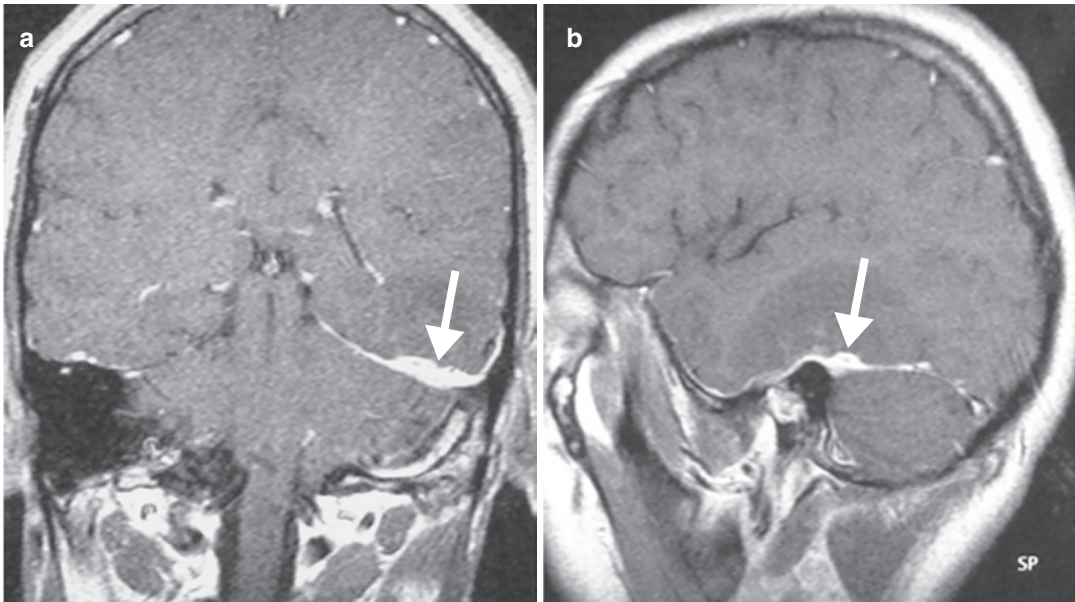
Tuberculous pachymeningitis. (a) Coronal and (b) sagittal contrast-enhanced T1-W MR images show left focal pachymeningeal enhancement along the cerebellar tentorium (arrows)
